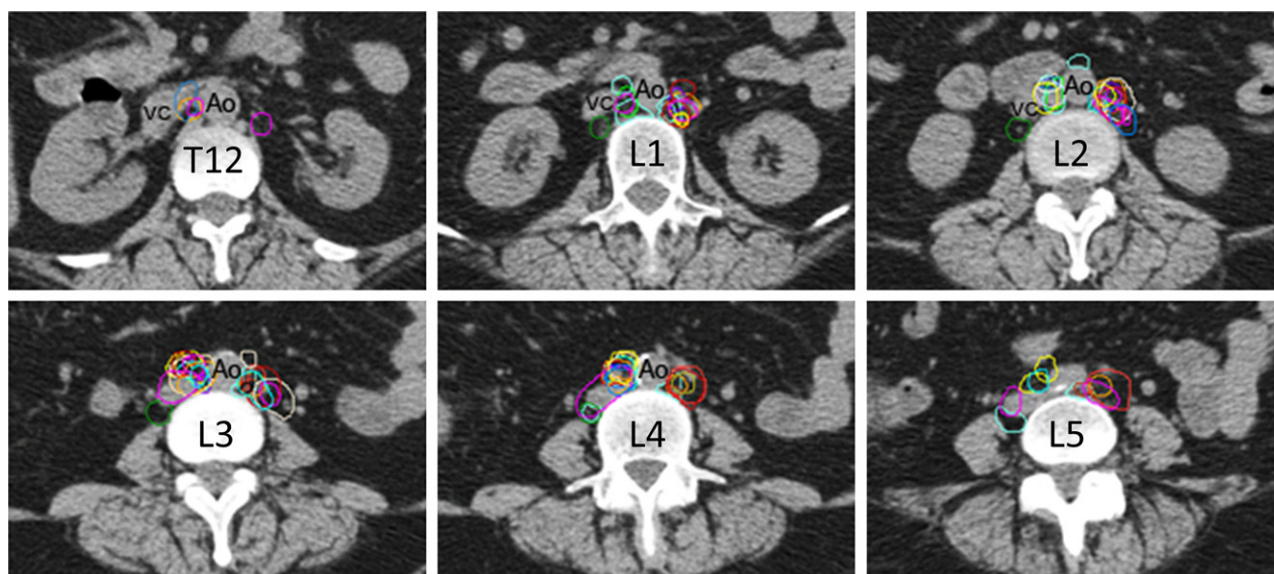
Axial location of fluorodeoxyglucose (FDG)-avid para-aortic lymph nodes in cervical cancer. Representative axial images (superior to inferior) depicting the location of 72 FDG-avid para-aortic lymph nodes. All lymph nodes from a single patient are contoured in the same color. Ao = aorta; VC = vena cava.
